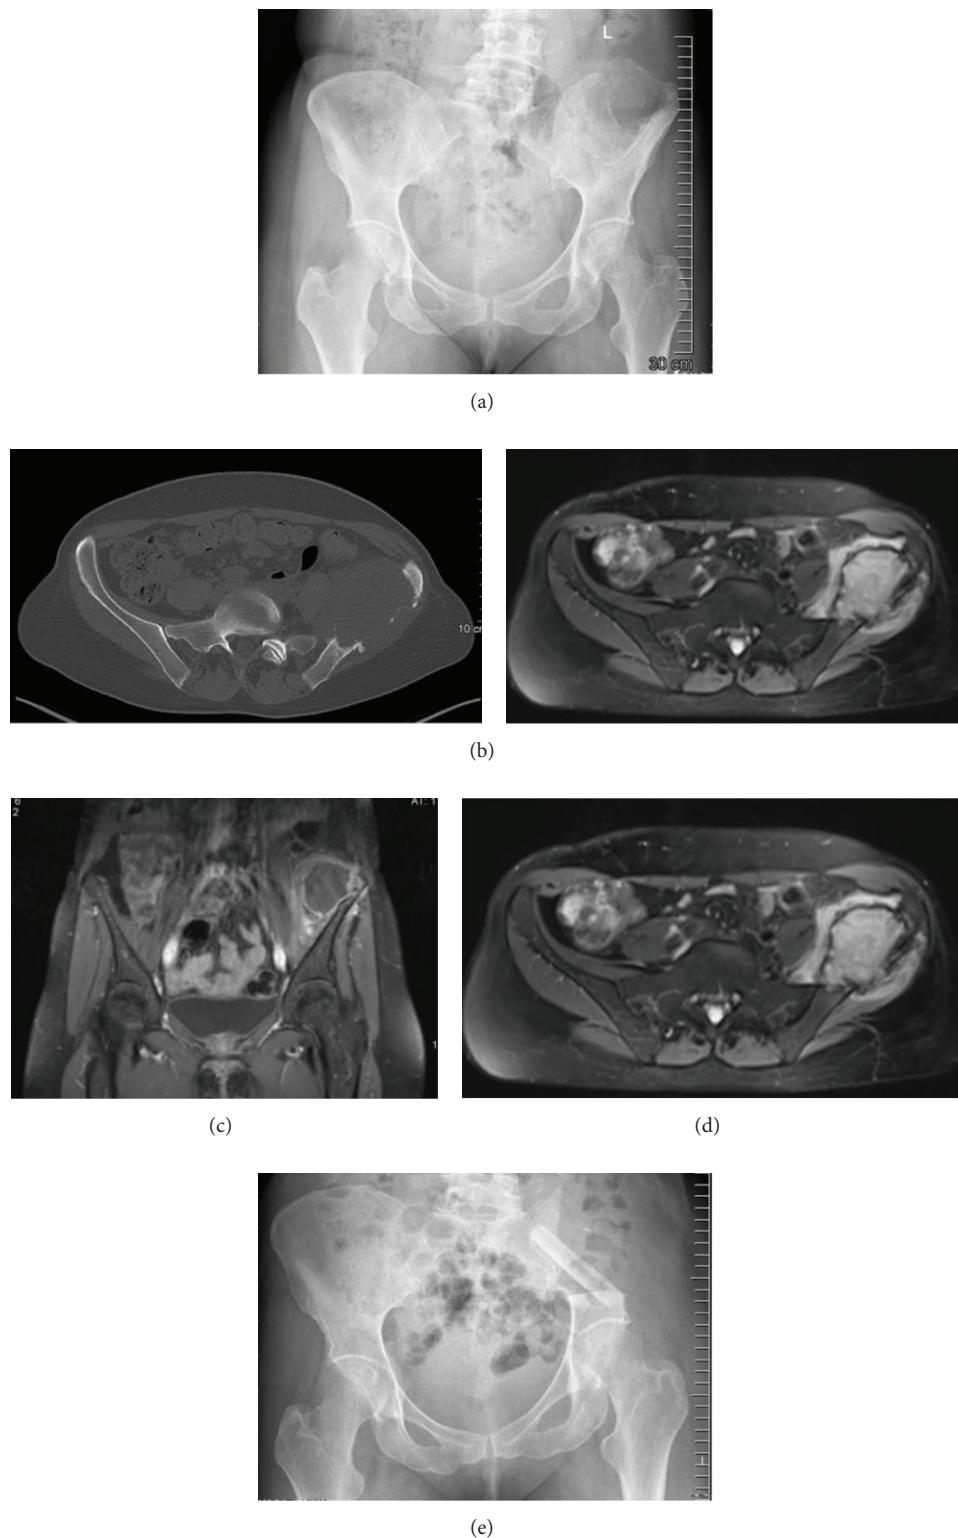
(a) Anteroposterior radiograph of the pelvis, showing a large osteolytic lesion of the left iliac bone (synovial sarcoma). (b) CT scan of the same patient showing the size of the tumor. Notably is the lack of matrix or calcification inside the tumor. (c) and (d) MRI scan of the same patient showing the intra- and extrapelvic size. (e) Postoperative X-ray after P1 resection and pelvic reconstruction stabilised with an autologous nonvascularised fibular graft.
